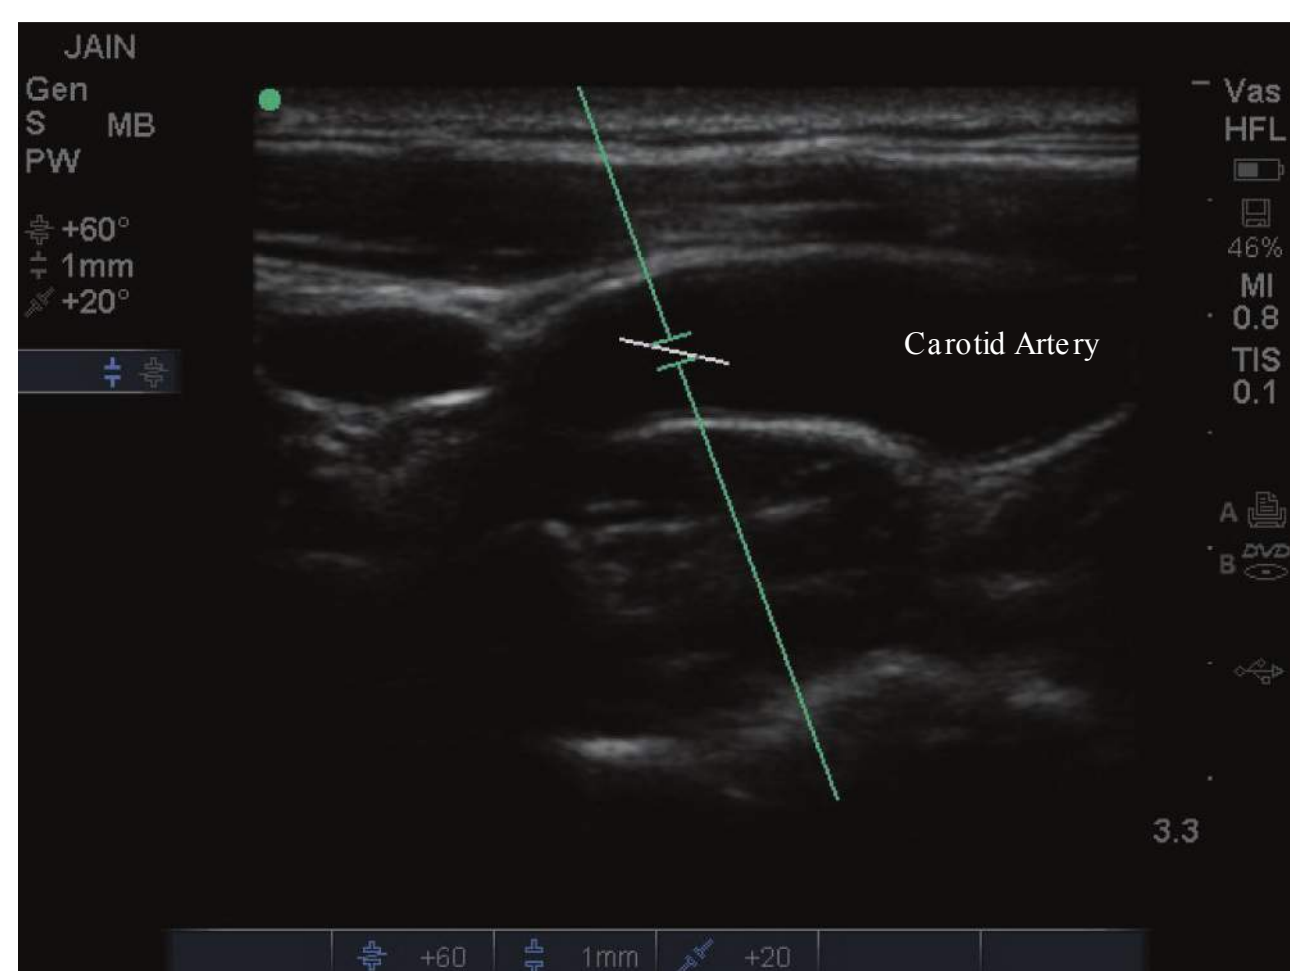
Doppler gate in the common carotid artery just below the bifurcation.
